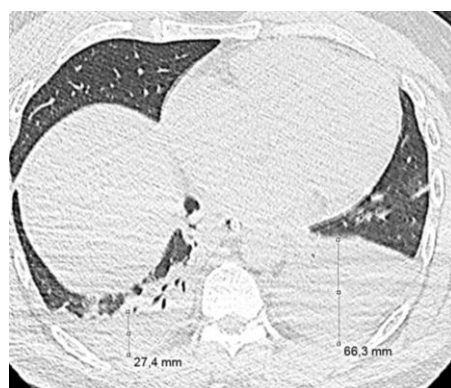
Pleural effusion view of the thoracic computed tomography image of the right and left hemithoraxes.
